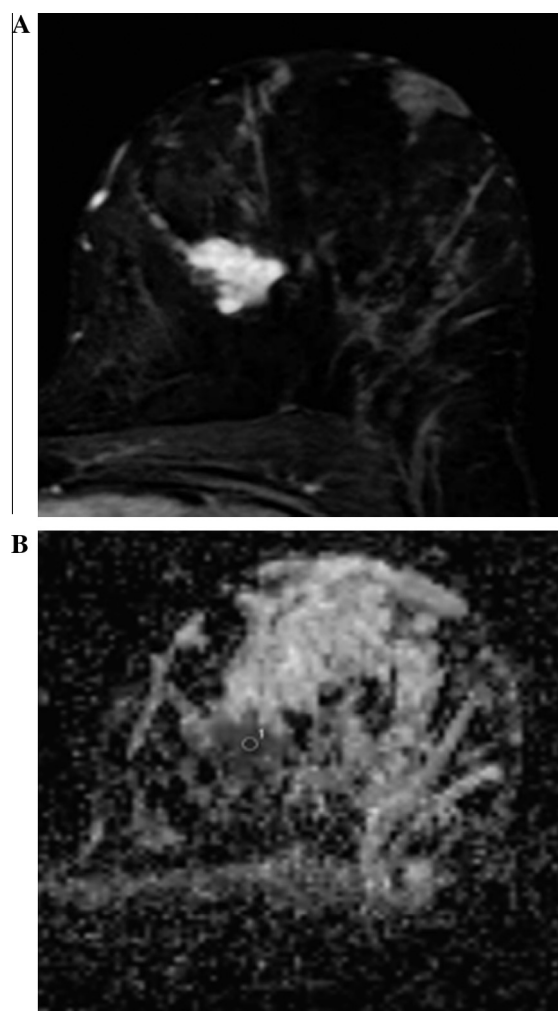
A – DCE-MRI shows an intensely enhancing irregularly outlined mass lesion in the upper inner quadrant of the left breast with a curvilinear tail of abnormally enhancing tissue seen directed anteromedially. B – ADC map revealed restricted diffusion with a low mean ADC value of $0.81 \times 10^{-3} \text{ mm}^2/\text{s}$.
